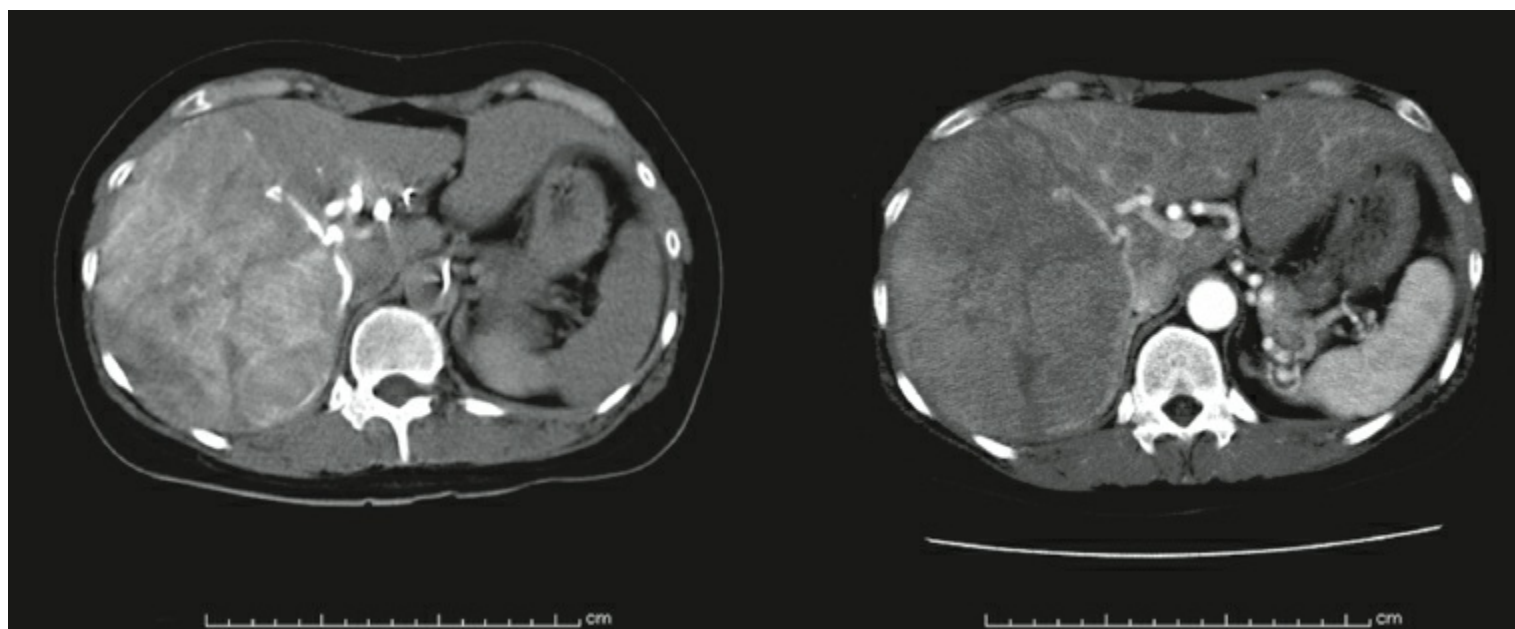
A huge hepatic adenoma found in a 31-year-old woman. Dynamic CT revealed early enhancement in the arterial phase (left) and iso- to hypodensity in the portal phase (right). This patient had no underlying liver disease and both serum alpha-fetoprotein level and plasma des-gamma-carboxyprothrombin level were within normal limits.
